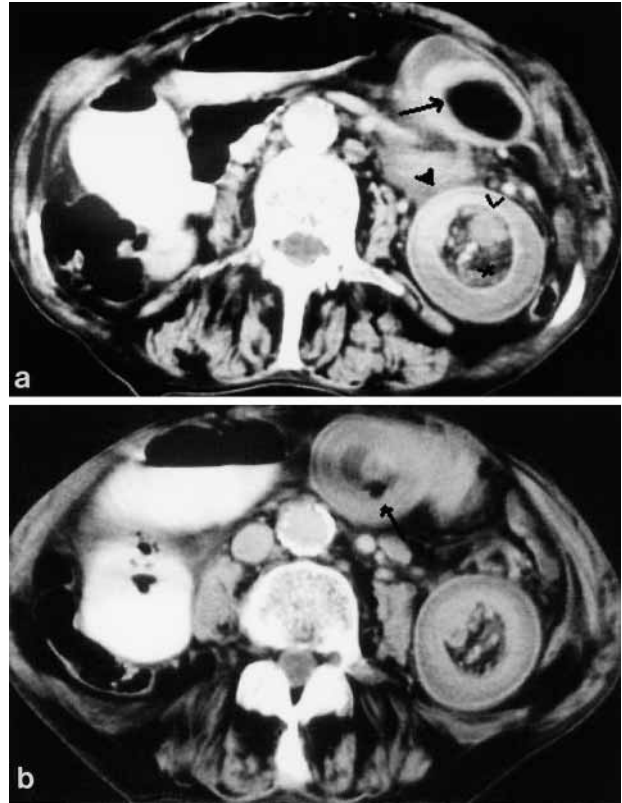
a) CT of jejunojejunal intussusception in a 69-year-old male patient. A round mass of fat density representing lipoma ( $\rightarrow$ ) was detected within the lumen of the intussusciptens. Another segment of intussusception is located just posteriorly to the anterior segment, and it is characterized by three layers: an inner layer of intussusceptum ( $>$ ), a mid-layer of mesenteric fat and vasculature ( $*$ ), and an outer thick-walled intussusciptens ( $\blacktriangleright$ ). b) Caudal CT reveals an outer, considerably thick-walled intussusciptens, associated with air within the wall ( $\rightarrow$ ), strongly suggesting bowel wall ischemia.
